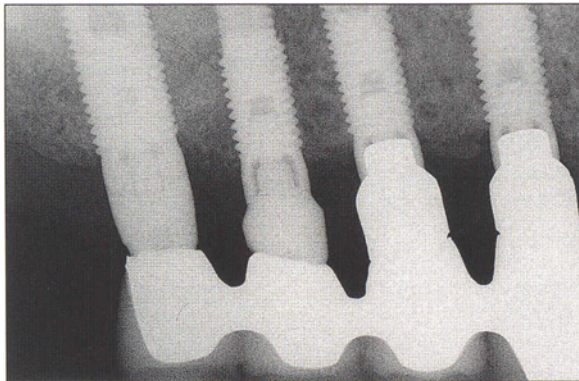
\ Periapical radiograph of the restored maxillary implants taken at a follow-up maintenance visit.
